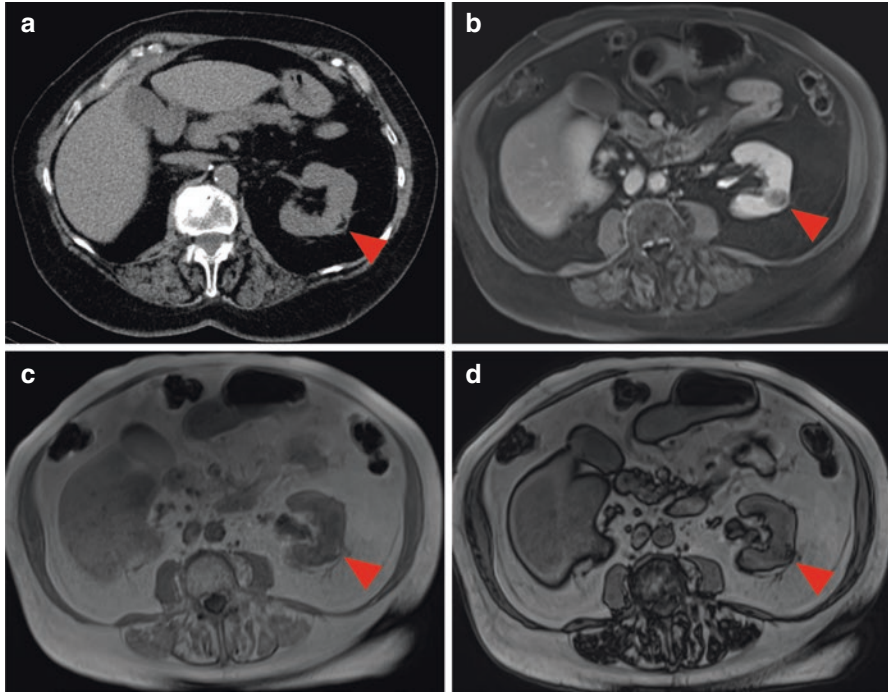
CT and MRI images of a renal AML. (a) Axial, non-contrast CT image of a patient with a left-sided renal mass containing macroscopic fat (red arrowhead). Note that the attenuation of the fat in the mass is identical to the perinephric fat surrounding the kidney. (b) Axial, T1, fat-saturation, post-contrast MR image in the same patient delineates the borders of this relatively hypoenhancing tumor and also demonstrates the presence of macroscopic fat. Just as on CT, the crescentic area of fat within the AML appears identical to the perinephric fat. (c) Axial, in-phase and (d) axial, out-of-phase MR images show the area of macroscopic fat in the AML as bright/high signal on the in-phase image (c), whereas the periphery of the macroscopic fat becomes dark/low signal on the out-of-phase image. This finding is known as the India ink artifact
